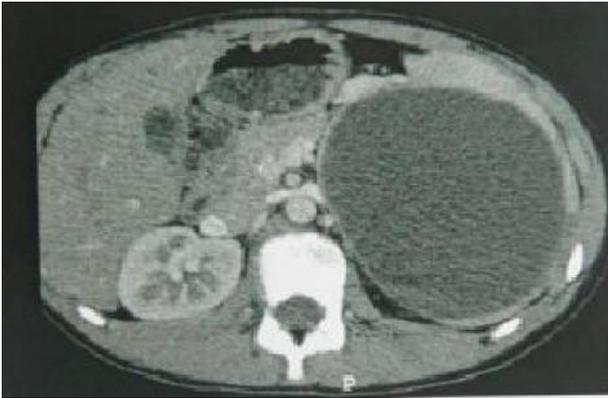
Abdominal CT showing the huge cystic mass of the spleen.
